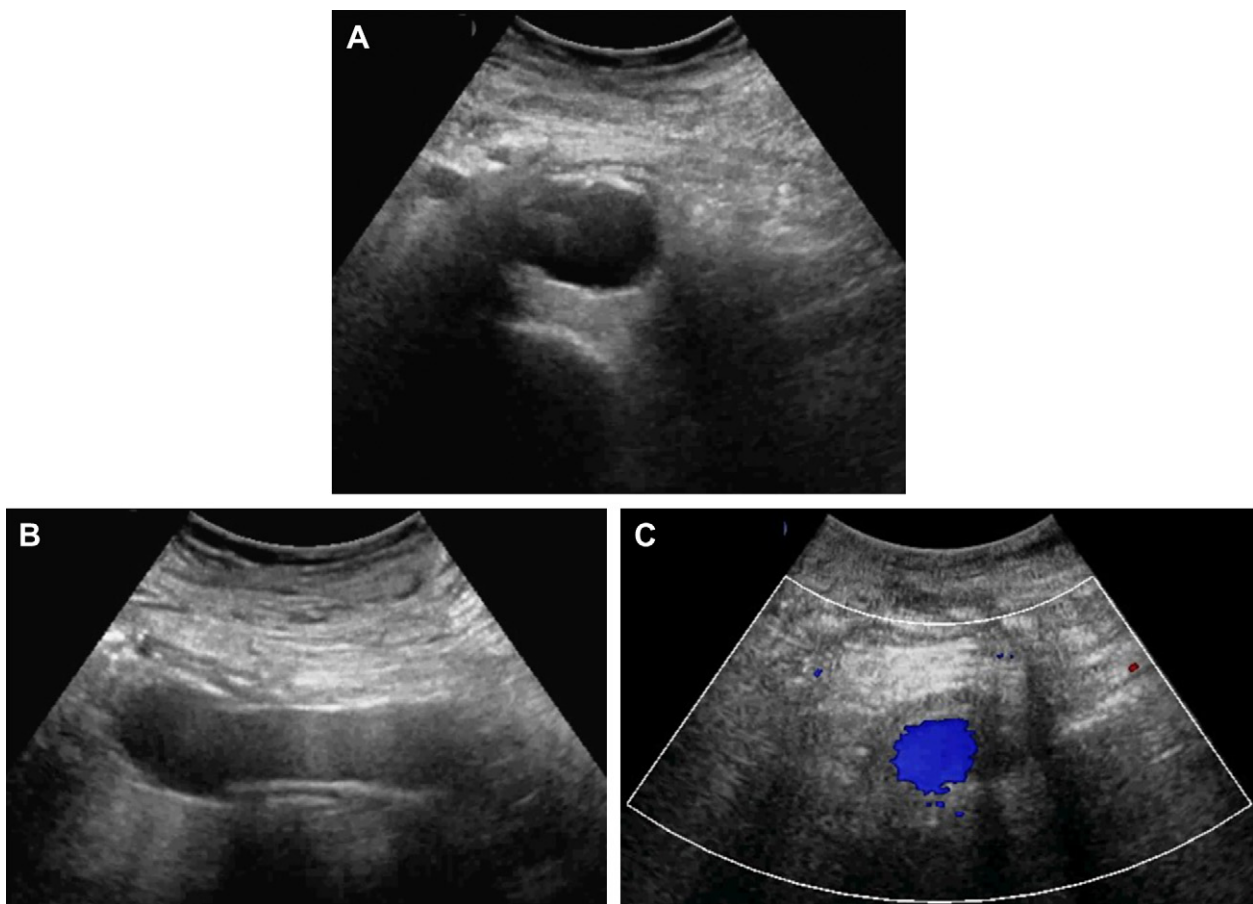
In the post-surgical phase, ultrasound can be used to monitor the diameter of the prosthesis and to detect stenosis and occlusions. Trasversal view (A, C); longitudinal view (B).
